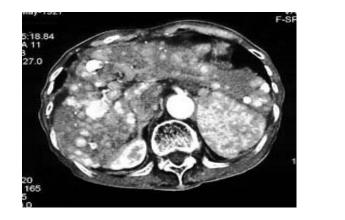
This figure gives two examples of exclusion criteria. In (Fig. 1A), the CT shows multinodular advanced hepatocellular carcinoma while (Fig. 2B) shows an ultrasonographic view of a lesion adjacent to the gallbladder.
